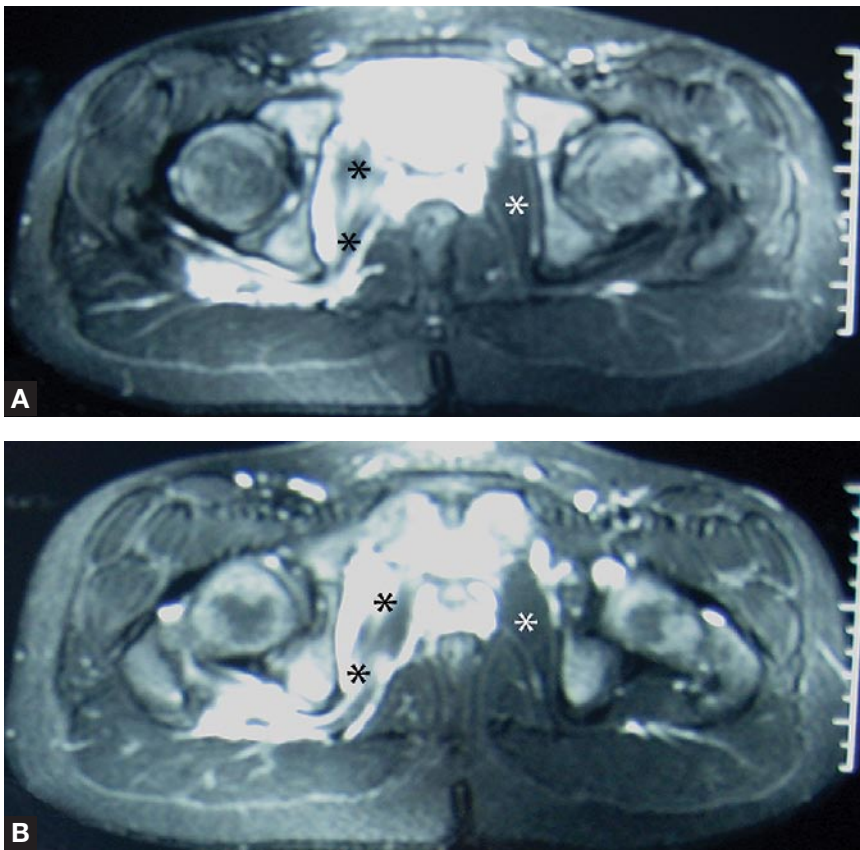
(A, B) Sequential axial slices from a T₂-weighted magnetic resonance imaging of the pelvis. The asterisks point to the obturator internus tendon as it courses around the ischial spine toward the greater trochanter. The black asterisks mark the injured and the white asterisks mark the uninjured sides of the pelvis. There is asymmetric fluid signal intensity around the obturator internus.
